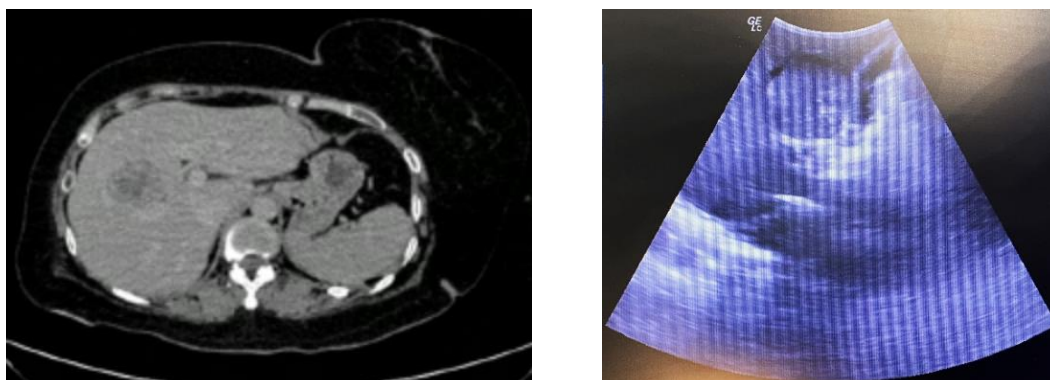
A, CT scan during surveillance, liver metastases was found at segments 4B-5; B, Intraoperative sonography for PSLS
